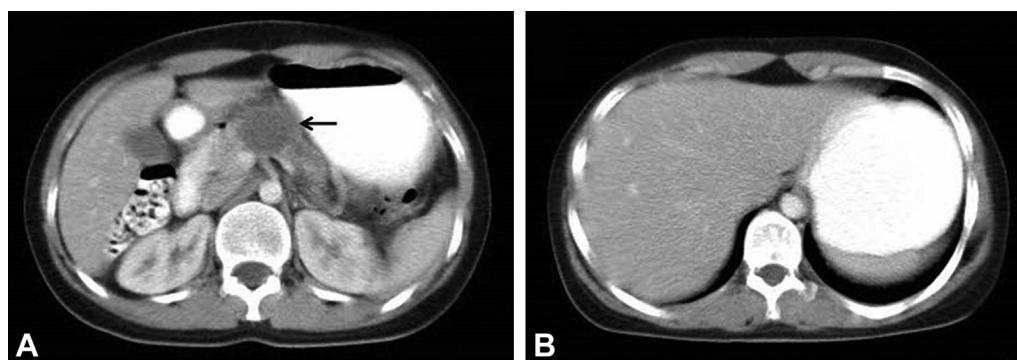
A, Abdominal CT scan demonstrating a mass lesion in the pancreatic body (*black arrow*). B, No cystic lesion is seen in the liver.
